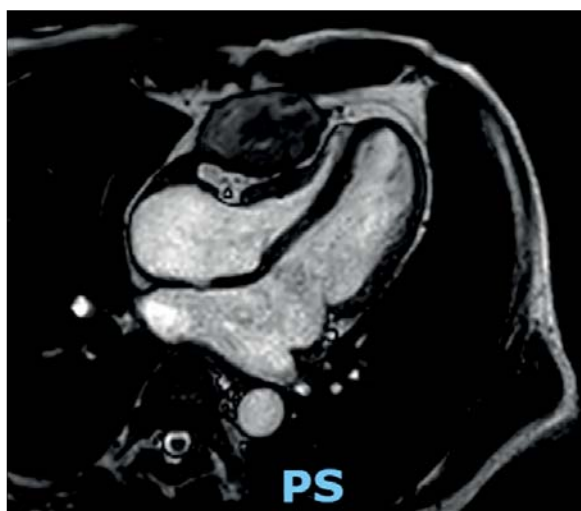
The magnetic resonance imaging showing a intrapericardiac lesion of 58.1 mm by 6.7 mm with irregular margins, heterogeneous in all the sequences, predominantly hypointense.
